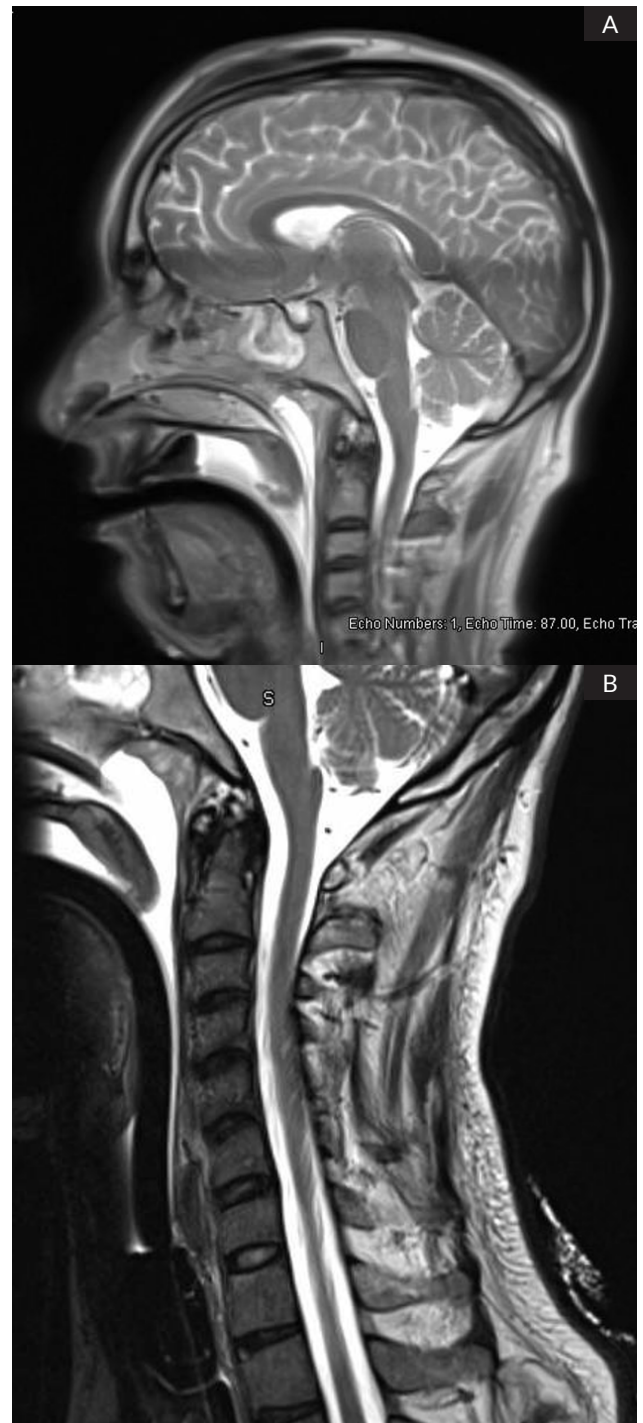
MRI of A) brain and B) spine.
